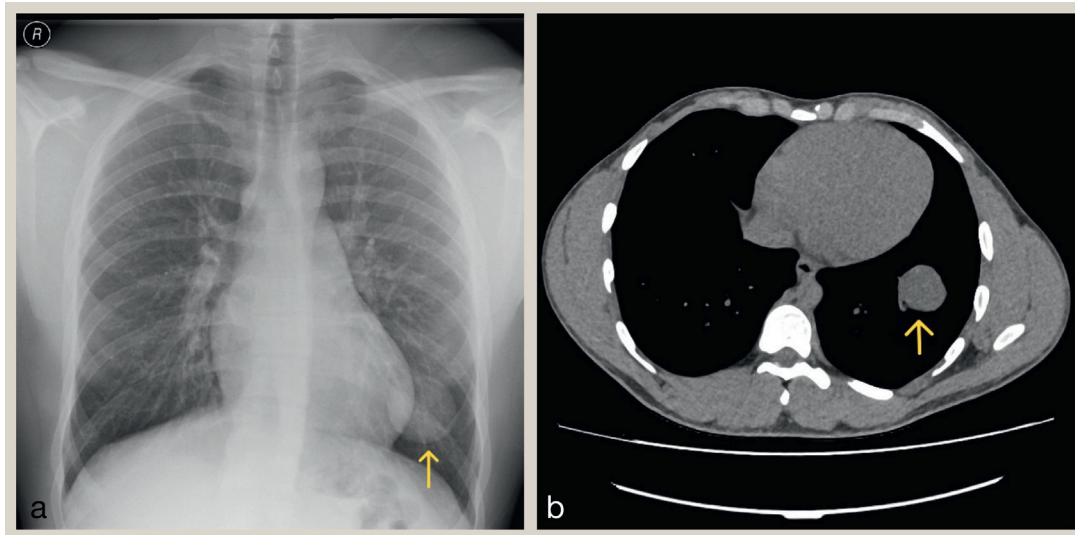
Radiological appearances of the lung lesion. Chest X ray (a) and CT scan (b). Arrows pointing to the lesion.
